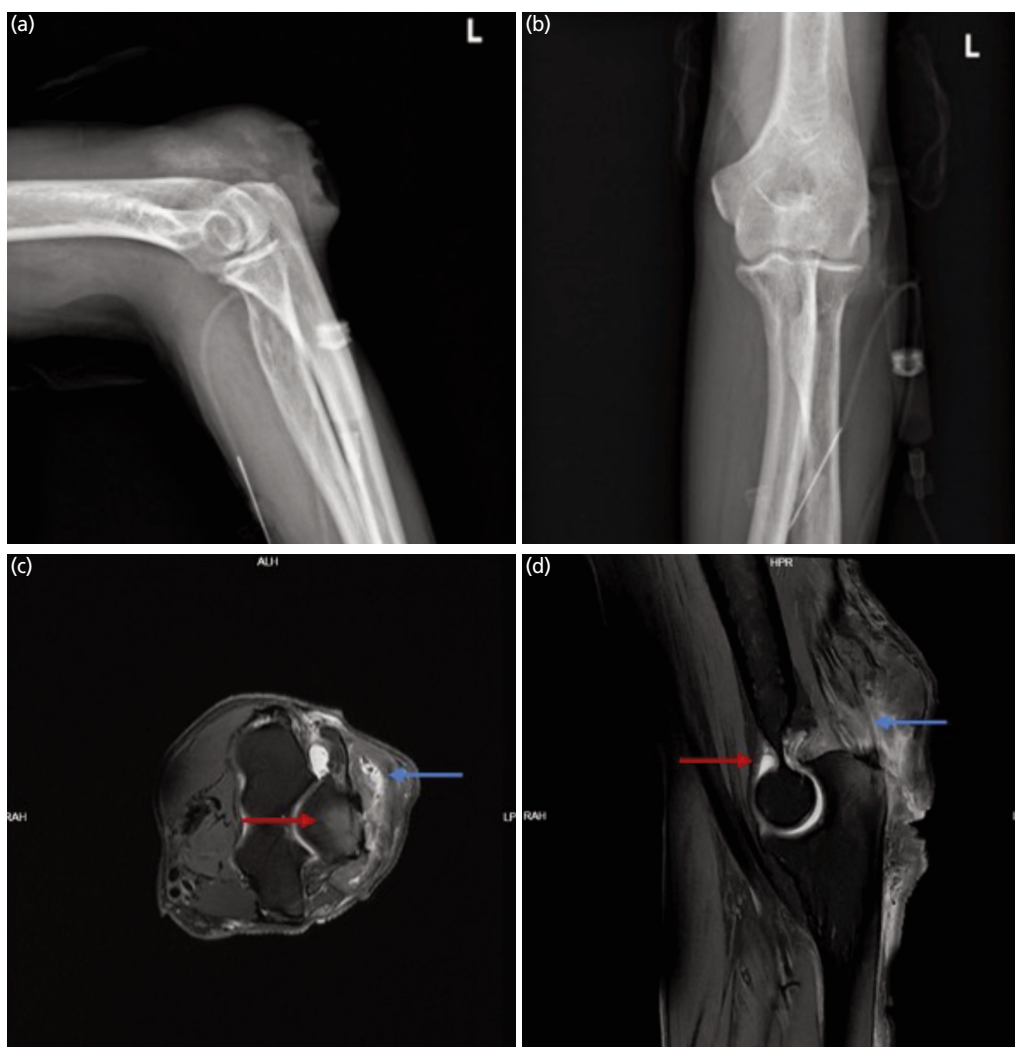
Radiograph of the left elbow, (a and b) Soft tissue swelling around the elbow joint. MRI of the left elbow, (c) Red arrow: bone marrow edema of the olecranon, and blue arrow: subcutaneous gouty tophi. (d) Red arrow: joint effusion, and blue arrow: triceps tendonitis.
